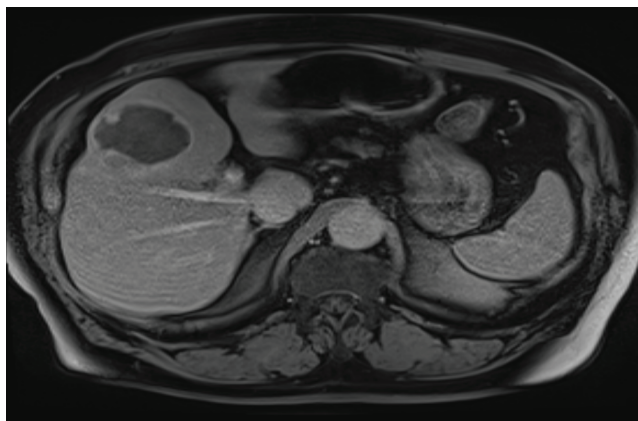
MRI 3 month after the procedure follow up
